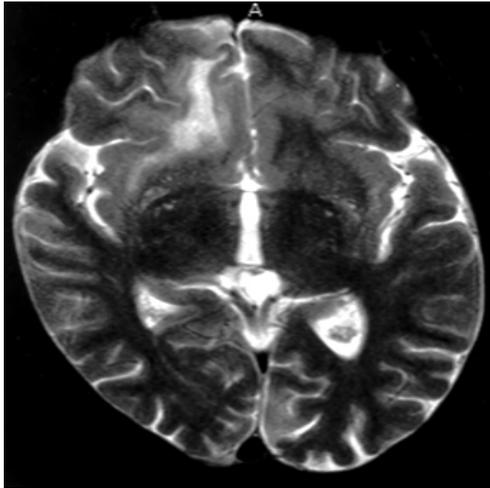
A sharply demarcated hyperintense lesion without mass effect is seen in this T2-weighted image in the subcortical right frontal white matter suggestive of PML
